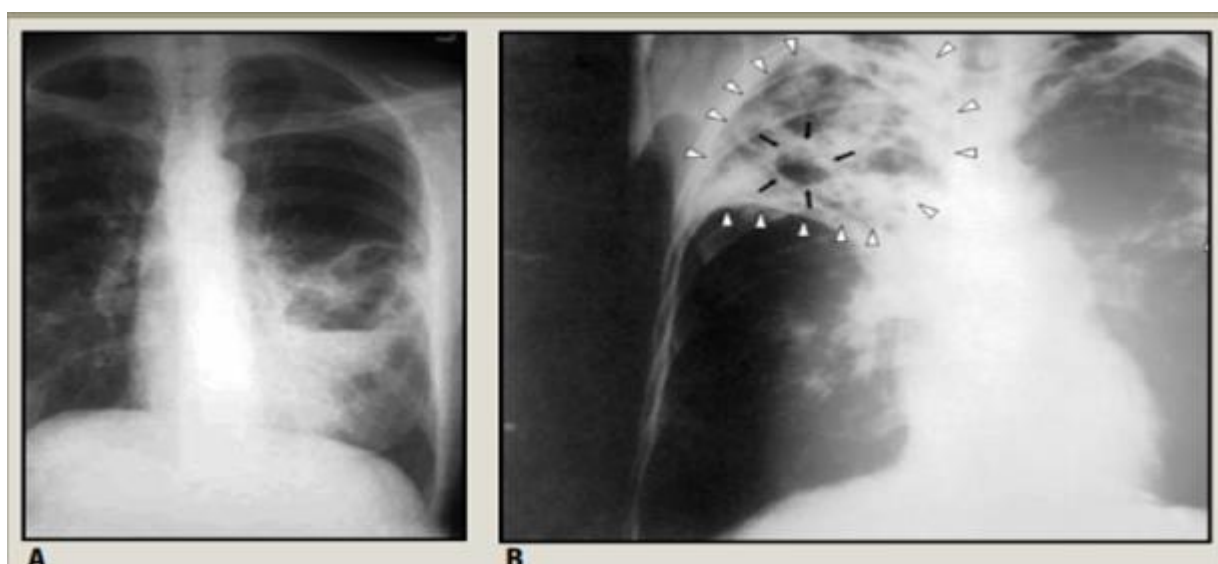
Chest radiography in pulmonary TB. A, Infiltration in left lung. B, Bilateral advanced pulmonary tuberculosis and cavitation in apical area of right lung. (Thrupp *et al*, 2004).
